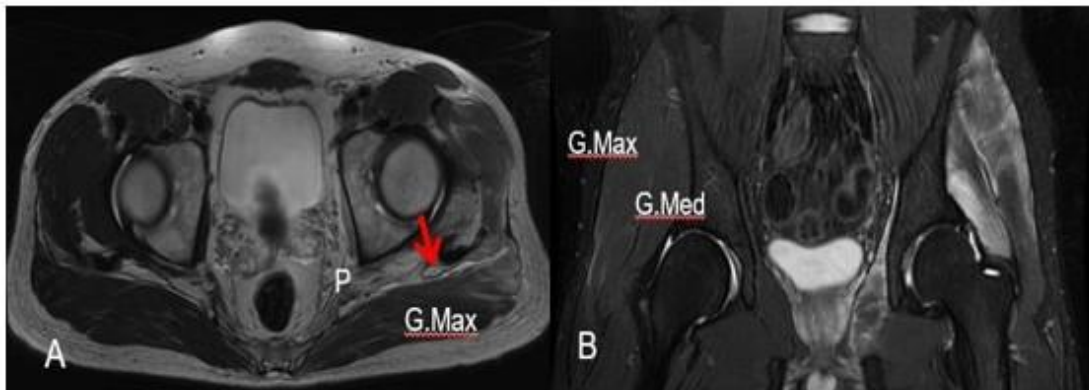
Axial (A) and coronal (B) MRI images of left spontaneous gluteal rhabdomyolysis. Increased signal intensity on T2-weighted images in left gluteus maximus, medius, minimus, piriformis muscle and soft tissue around the left sciatic nerve (arrow). G. Max; Gluteus maximus, G. Med.; Gluteus medius, P; Piriformis.
